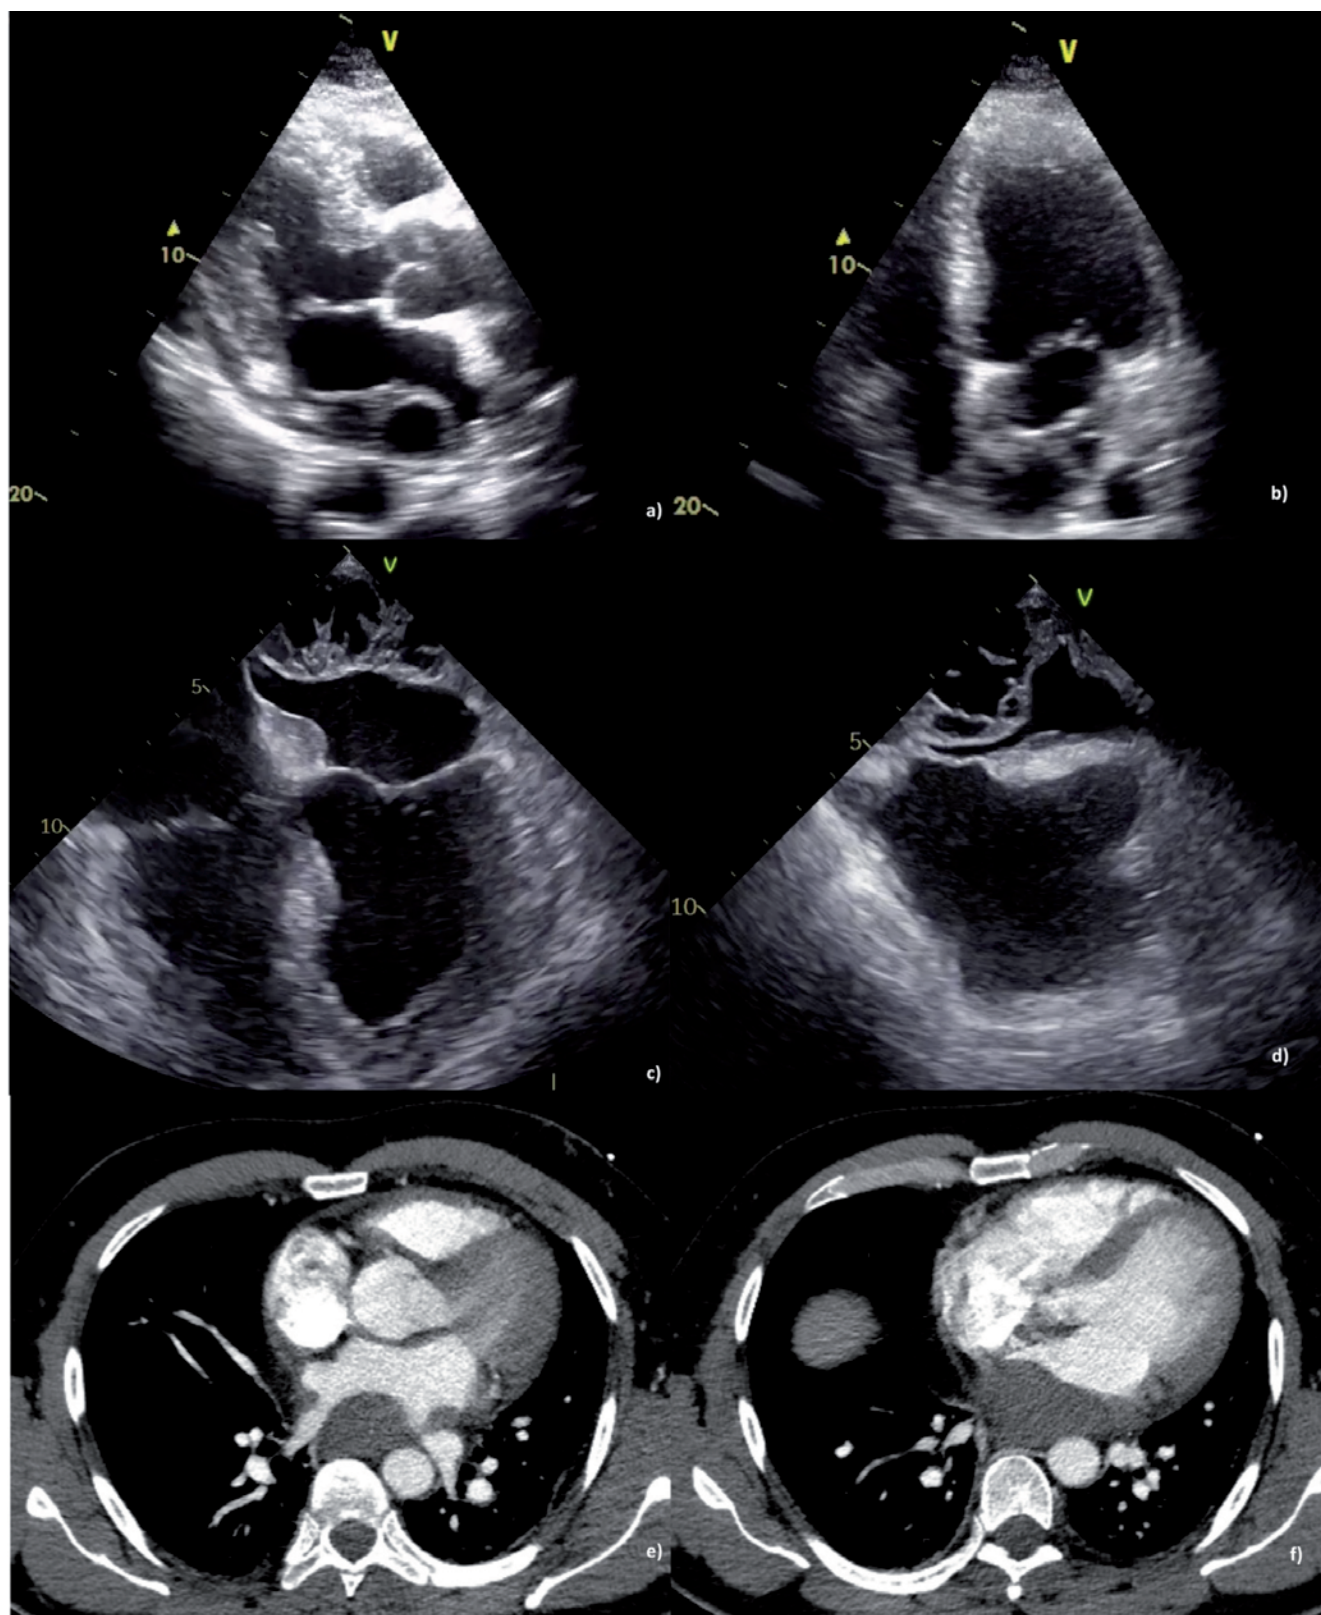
Echocardiographic and computed tomography images at admission showing the left atrial mass. a) Parasternal long-axis view; b) transthoracic four-chamber view; c) mid-esophageal four-chamber view; d) mid-esophageal bicaval view; e, f) computed tomography angiography images highlighting the hypovascularized nature of the mass.
